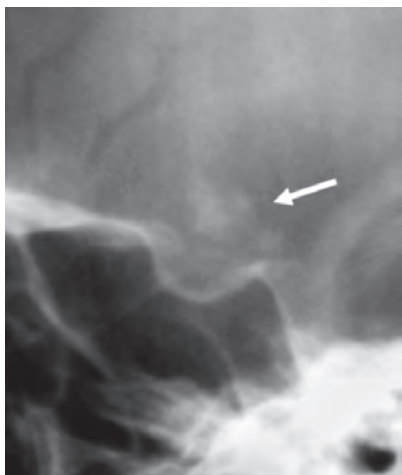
X-ray lateral view in a patient with craniopharyngioma showing suprasellar calcification
